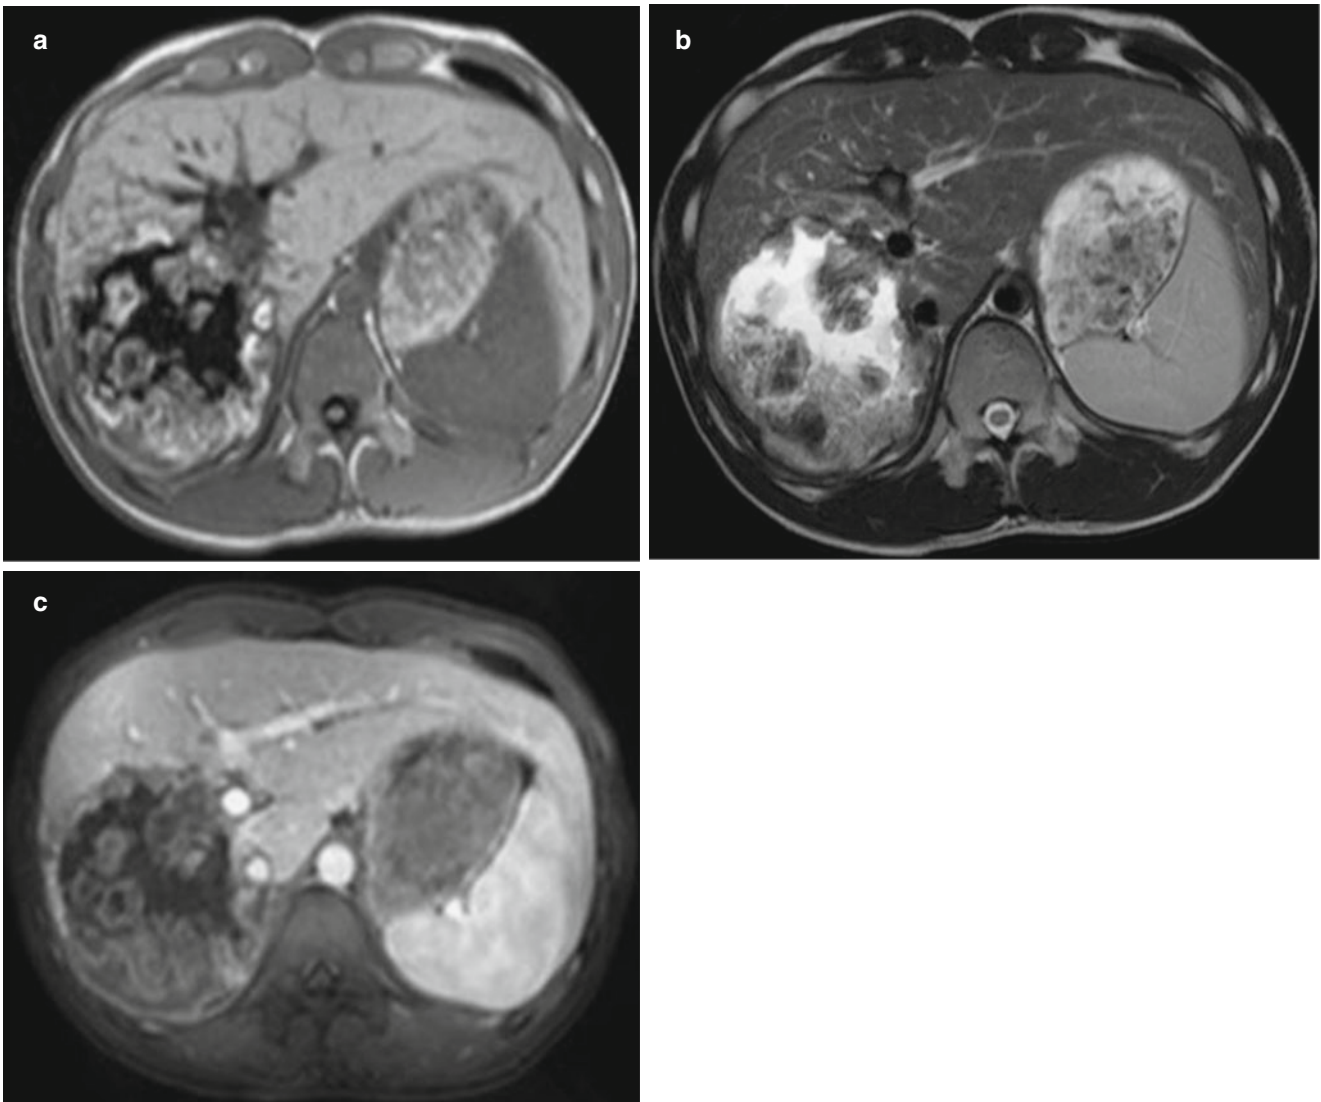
Hepatic alveolar hydatidosis. (a, b) MR imaging demonstrates alveolar hydatidosis lesion in the right liver lobe, with uneven signal, irregular shape, and blurry boundary. In the lesion, there are patches of calcification. (c) Contrast imaging demonstrates well-defined boundary of the lesion and no enhancement of the lesion
